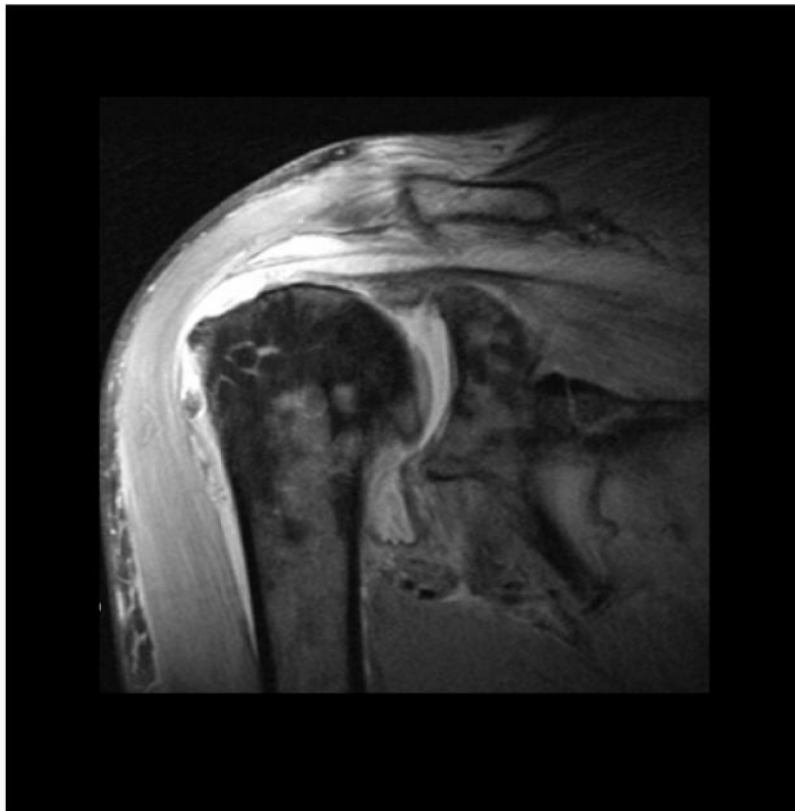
MRI Gadolinium coronal cut shows moderate joint effusion with thick synovial enhancement suggestive infectious process
